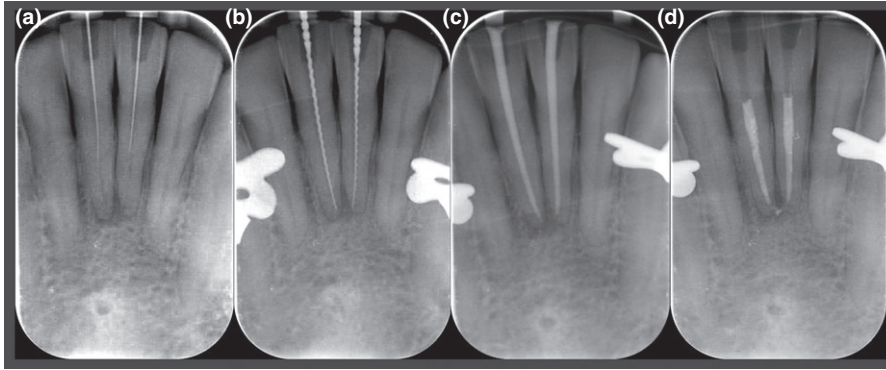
Radiographs taken during root canal treatment. (a) After finalization of Guided Endodontics for orientation purposes, (b) length measurement, (c) masterpoints, (d) final filling with removal of coronal segment of root filling.
